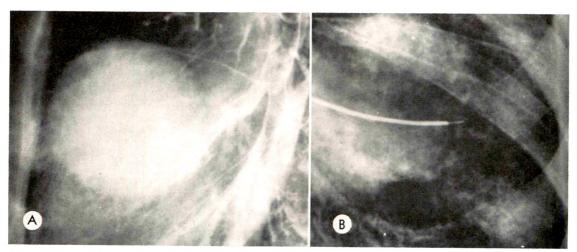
Man, aged 65 years, presented with a history of shortness of breath for 6 months, moderate dyspnea on exertion, tiredness, lassitude, and occasional blood-tinged sputum. He had a chronic cough for many years, had smoked I pack of cigarettes per day for many years and had been treated for pulmonary tuberculosis 4 years previously. He had noted no loss of weight. On examination he appeared thin, but was in no acute distress. Coarse rales were noted over the right base, and there was a Grade II apical systolic murmur. Physical examination was otherwise essentially negative. Chest roentgenogram revealed a round, well circumscribed mass in the middle lobe on the right (A). This mass had no specific internal characteristics and had well defined margins. At bronchoscopy, it was noted that the orifice of the middle lobe appeared somewhat narrow but had smooth margins. A biopsy obtained at bronchoscopy revealed bronchial mucosa with focal squamous metaplasia. Bronchial brushing (B) revealed abundant highly atypical cells consistent with malignancy. This patient subsequently underwent radiation therapy followed by pneumonectomy.
